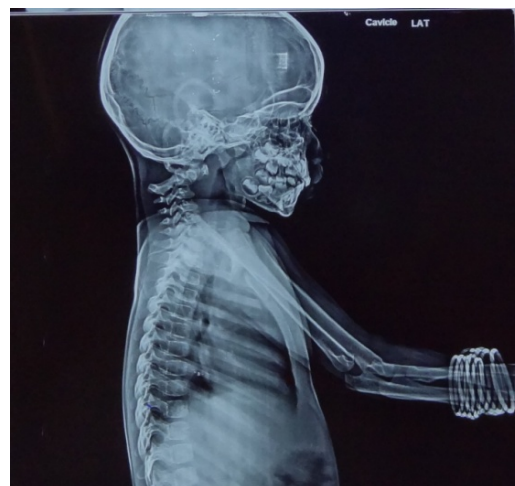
Preoperative X-Ray shows anterior subluxation of C1 over C2
